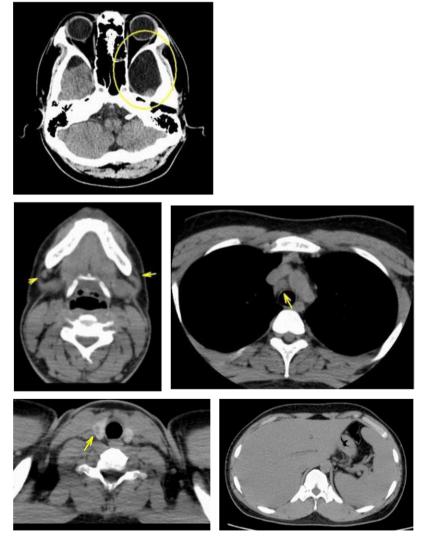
Computed tomography revealed the presence of an arachnoid cyst, enlargement of the cervical/mediastinal lymph node and splenomegaly.
